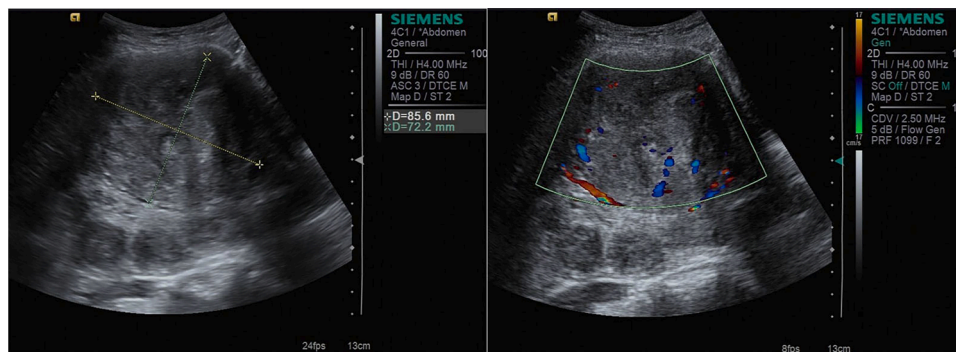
Ultrasonic Images of Uterine leiomyoma in this case. Irregularly contoured uterine structure adorned with hypoechoic masses measured 85 mm × 72 mm.
